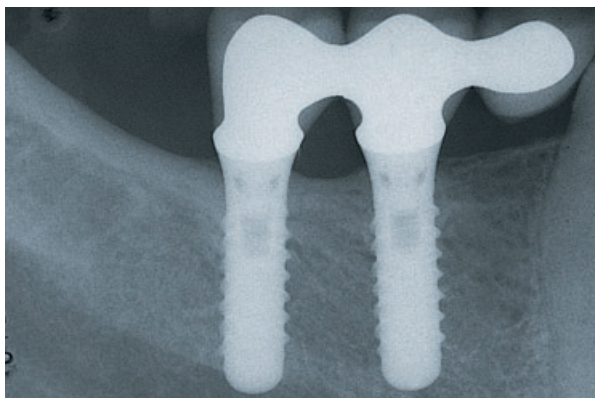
The 6-year radiograph displays stable bony conditions around the two implants supporting a cemented suprastructure with a premolar-sized mesial cantilever unit.
